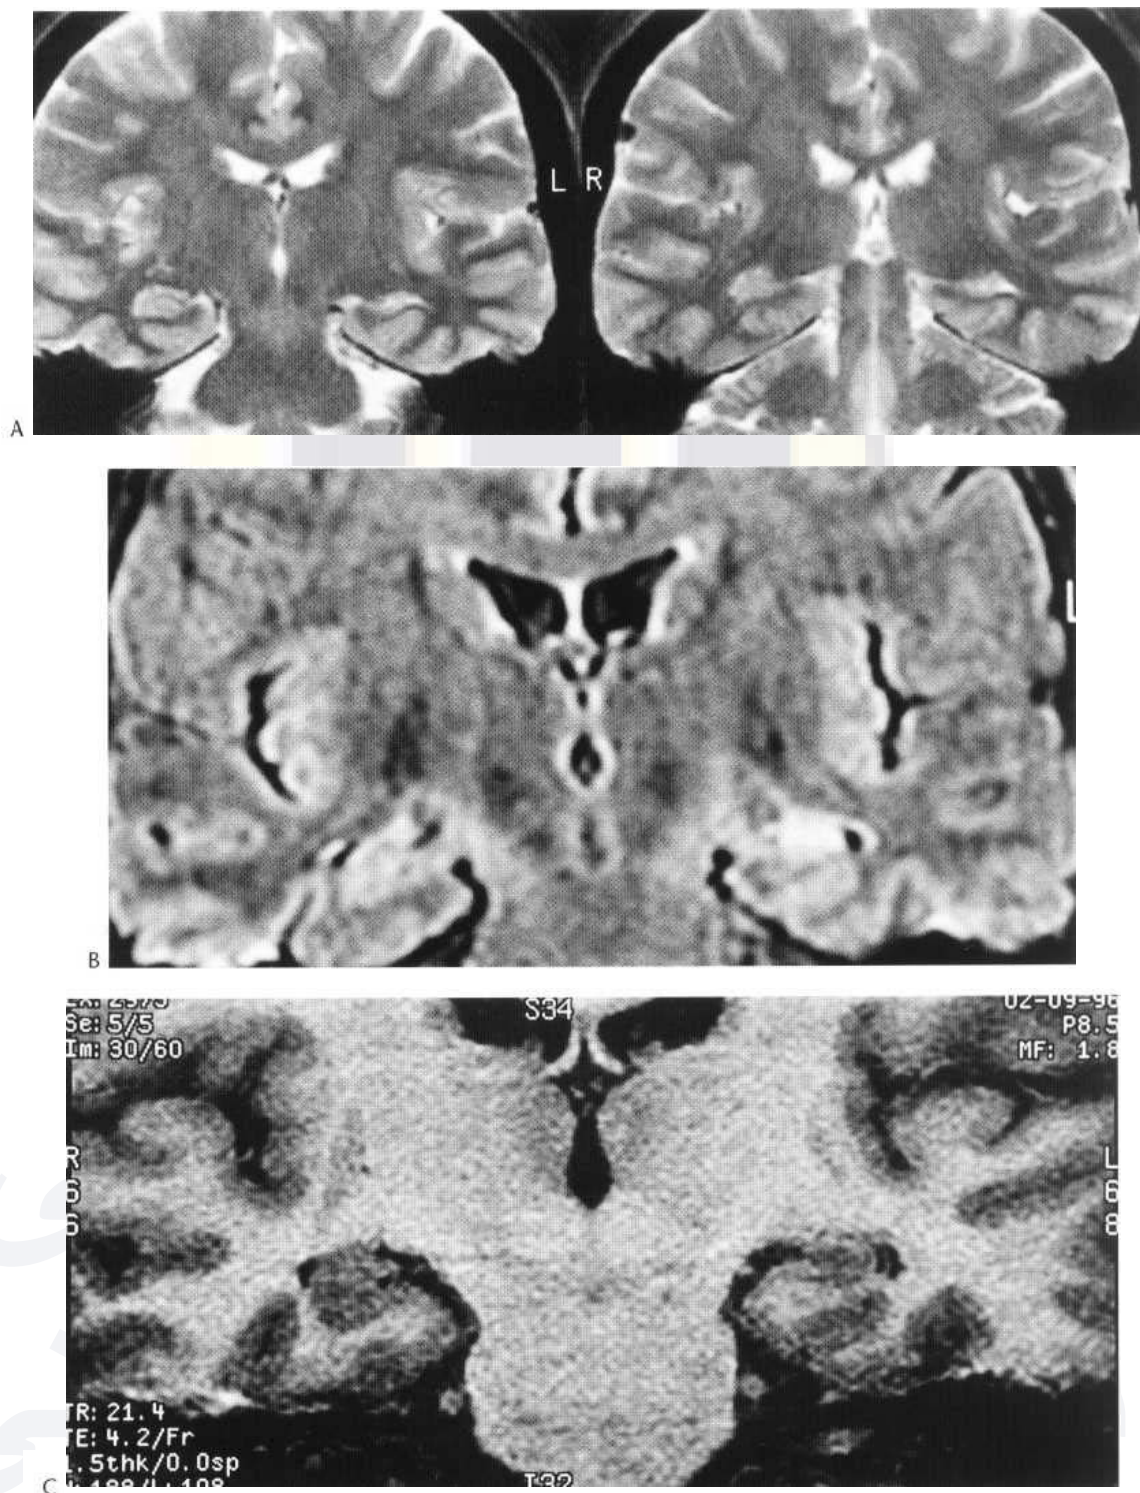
(A) Coronal MRI sections, T₁-weighted, through hippocampal bodies, corresponding to level E of Fig. 58.76A. The left hippocampus is smaller than the right and shows higher signal. Hippocampal sclerosis. (B) Coronal MRI (FLAIR) image at level of hippocampal body accentuating high signal in left hippocampus. (C) T₁-weighted image at similar level from a 3D accumulation, showing the left hippocampus to be much smaller than the right.
